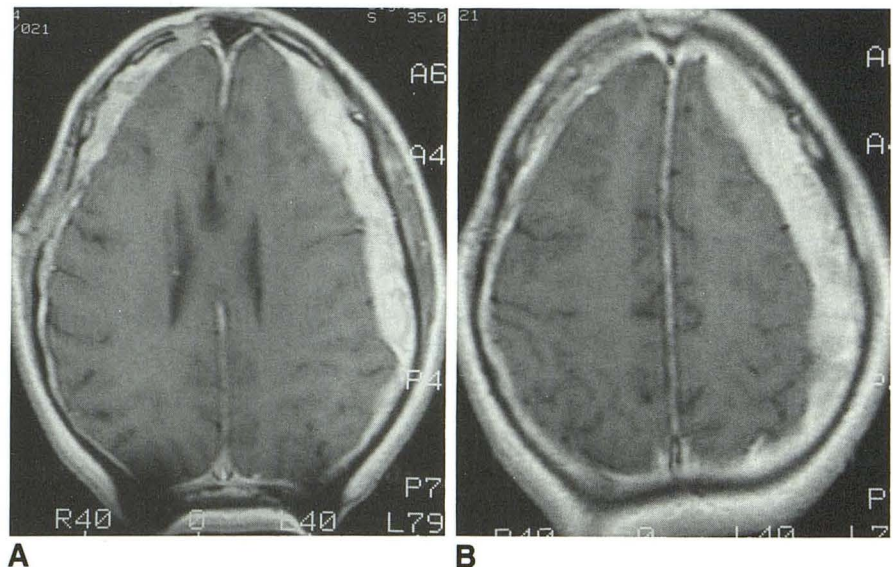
A and B*, Two months after shunting of the patient's hydrocephalus, and in the absence of tumor-specific therapy, repeat MR imaging (500/20/1) with the same dose of gadolinium as in Figure 1 reveals decompression of the lateral ventricles and resolution of leptomeningeal enhancement. Incidentally noted is the interval development of bilateral (left greater than right) subdural hematomas containing high-signal intensity methemoglobin.
